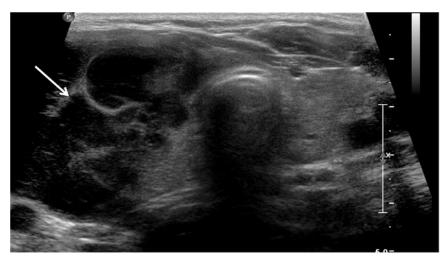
Thyroid ultrasound of a 70-year-old female reveals a hypoechoic, lobulated multiseptated mass (arrow) occupying the expected position of right thyroid lobe with extra-thyroid extension. Fine needle aspiration cytology reveals a thyroid lymphoma with extrathyroidal extension/infiltration.
